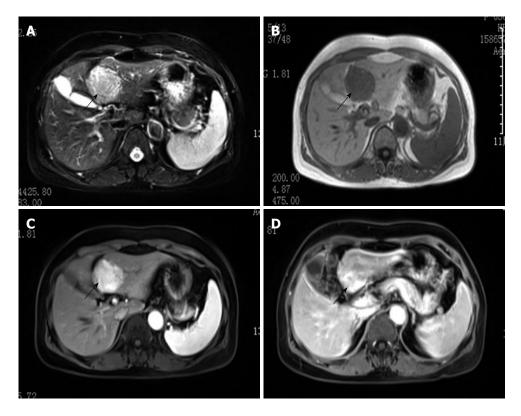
Magnetic resonance imaging manifestation of the female patient. The tumor had clear boundaries and showed high signal on T2WI (A, black arrow) and low signal in the plain phase (B); Hyperenhancement in the arterial phase (C) and delayed phase (D).
